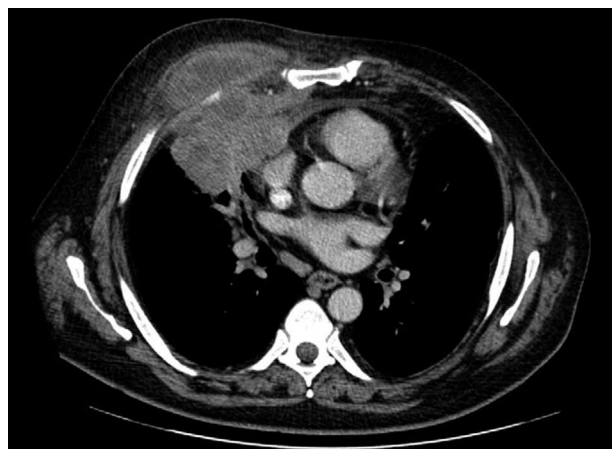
CT scan showing the mass-like consolidation in the middle lobe contains areas of low attenuation in keeping with necrosis and is causing rib and costal cartilage erosion; it extends directly into the anterior chest wall, deep to the pectoralis major muscle, where there is a multiseptated low-density collection.
